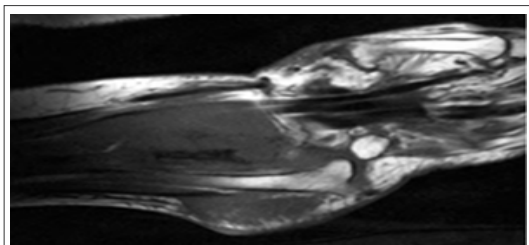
MRI - coronal view of the wrist (T1 weighted).
